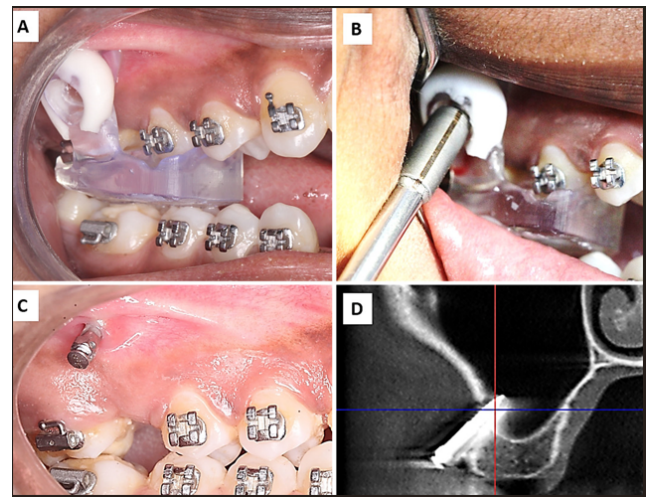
A. GIC coated implant guide., B. Guided bone screw placement., C. IZC in place, after removal of the guide, D. CBCT image showing the IZC in planned position.
